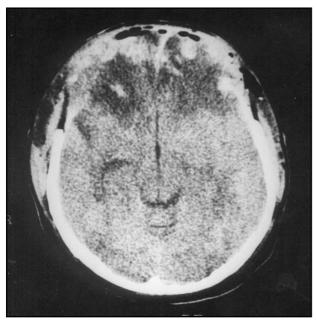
CT scan of patient 1 after bifrontal decompressive craniectomy.
